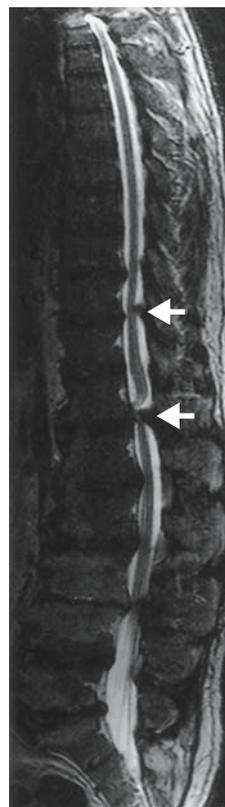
T2-weighted MRI of thoracic OLF. One severe and several moderate areas of compression by OLF can be seen. There is also cauda compression by disc degeneration in the lumbar area
